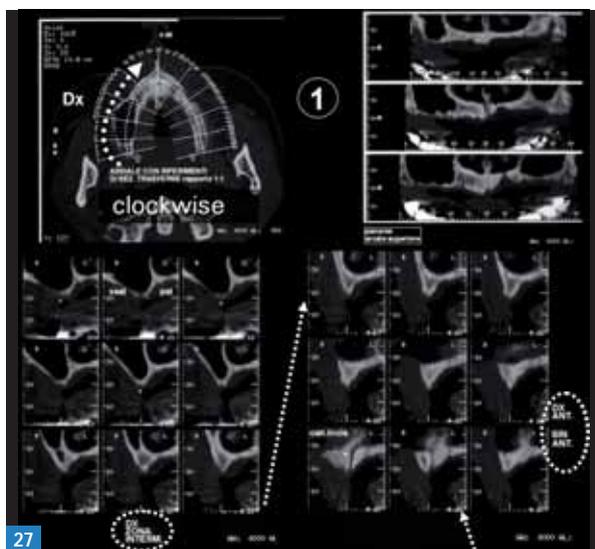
21 Cone-beam CT: cross-sectional image extrapolation from axial projection.
